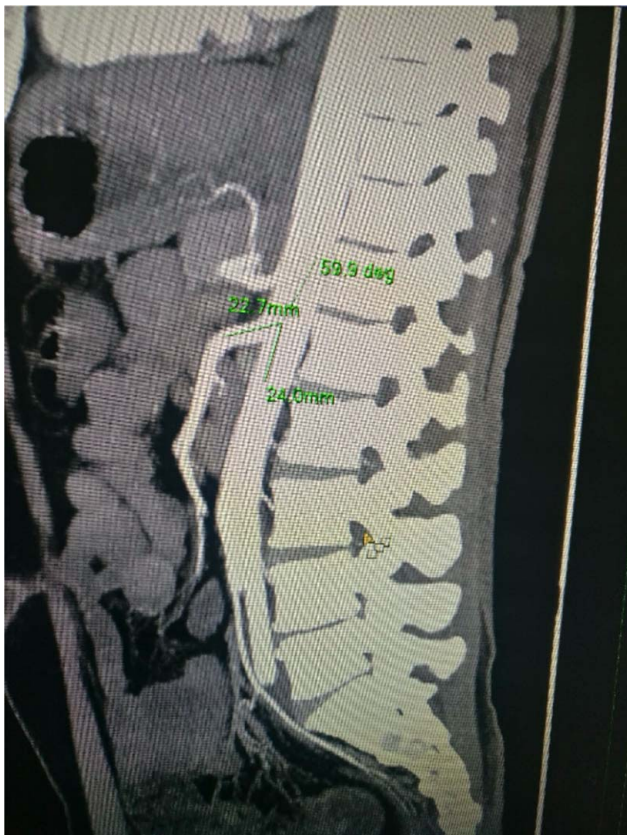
Sagittal section computed tomography image of the abdomen showing measurement of the aortomesenteric angle.
